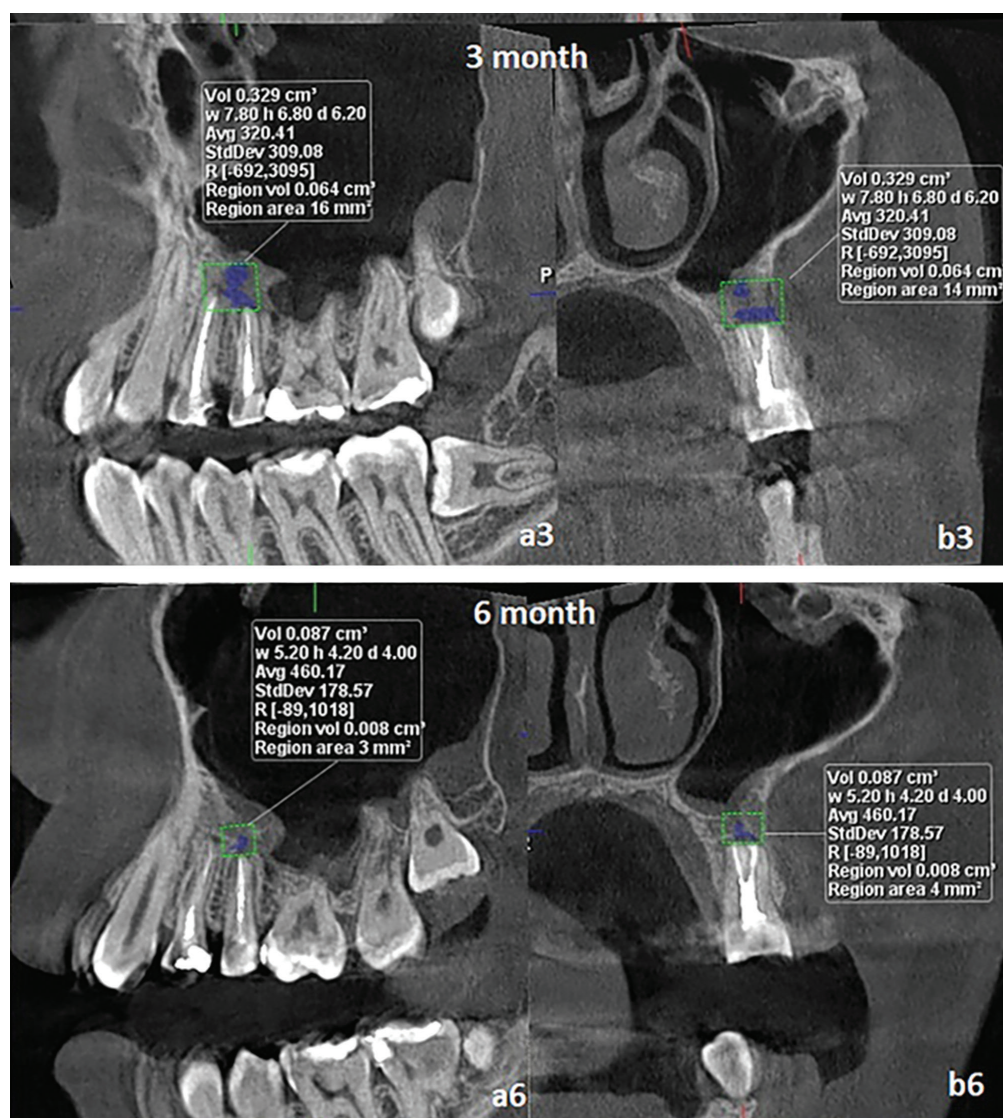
CBCT evaluation of teeth 24 and 25 three and six months after surgical treatment: (a3, a6) coronal section; (b3, b6) sagittal section.
